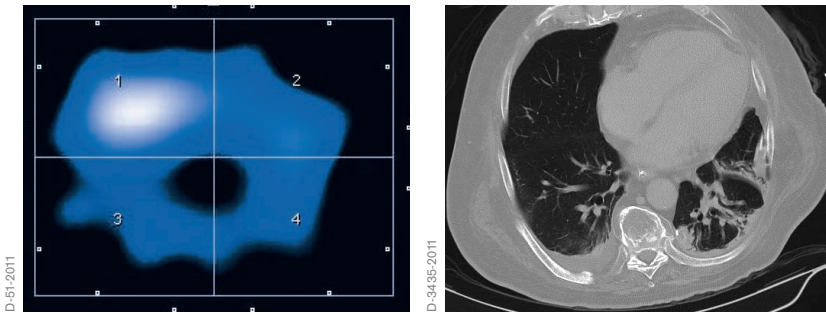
Tidal image and corresponding CT image of an ARDS patient
